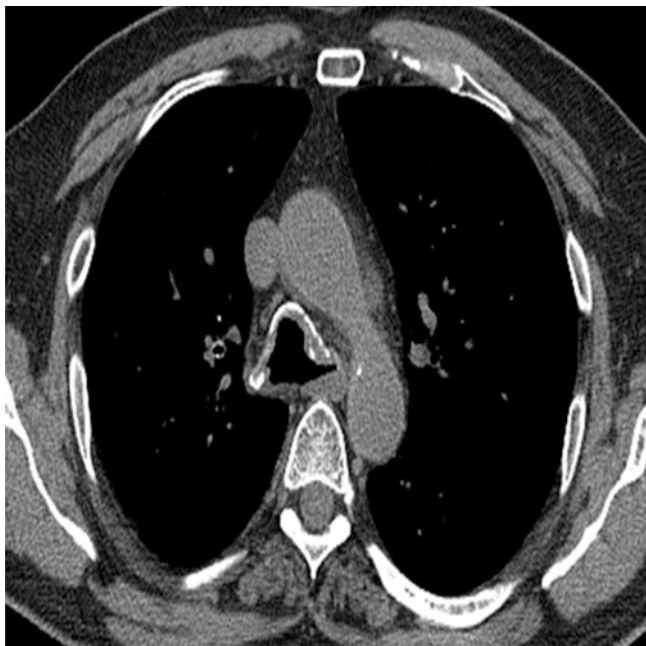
A CT scan of the chest of a 64-year-old man with tracheobronchial amyloidosis demonstrating nodular thickening of the tracheal wall with calcifications
